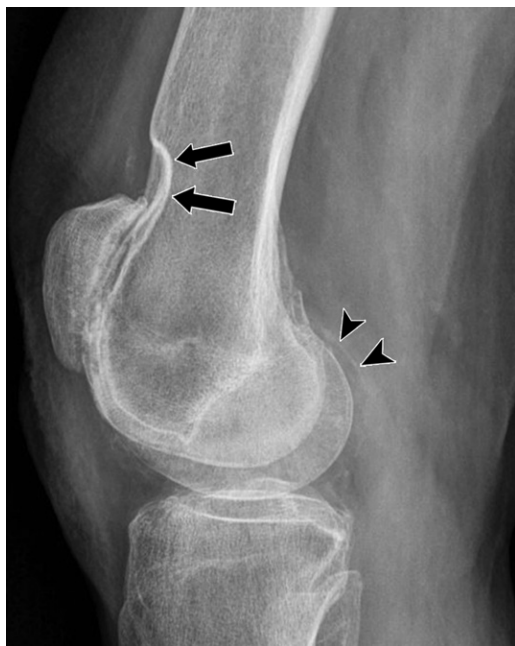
CPPD arthropathy in a 78-year-old woman. Lateral radiograph of the right knee shows severe patellofemoral arthropathy, out of proportion to the degree of femorotibial arthropathy. Note the scalloping of the anterior femoral cortex at the upper patella (arrows), characteristic of CPPD arthropathy. Faint chondrocalcinosis is evident at the posterior joint and capsule (arrowheads).
